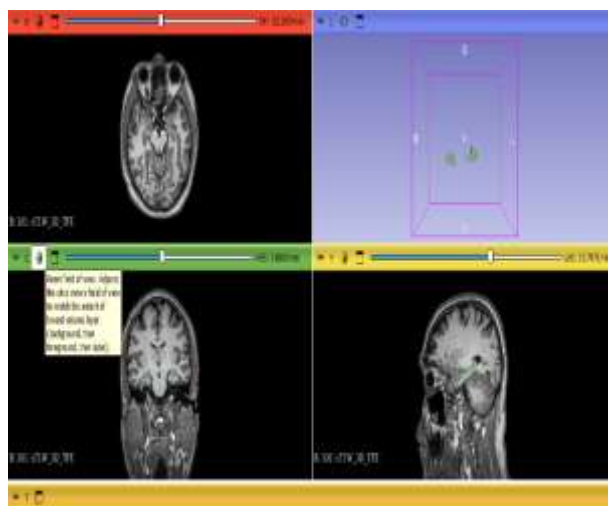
Normal T1-weighted MRI of brain showing outlines of the hippocampus in coronal, sagittal and axial and 3D view.
